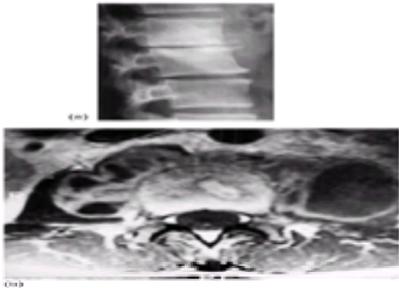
Paraspinal soft tissue mass in spinal tuberculosis. (a) The radiograph demonstrates narrowing of an upper lumbar disc space with reversal of the curve. There is destruction of the adjacent end-plates with reactive new bone formation anteriorly, and a soft tissue mass is demonstrated anterior to the affected disc. (b) The axial MR images demonstrate not only the erosive destruction of the vertebral body but also psoas abscesses. The images are obtained after intravenous gadolinium and show both areas of enhancement and necrosis in the psoas muscles as well as anteriorly in the retroaortic tissues.
